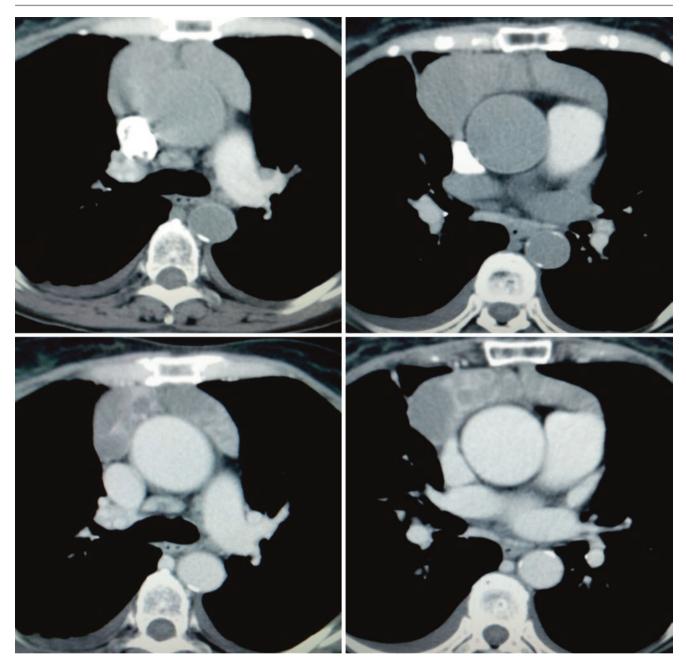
Chest CT images of a 69-year-old woman complained of fever for 45 days
